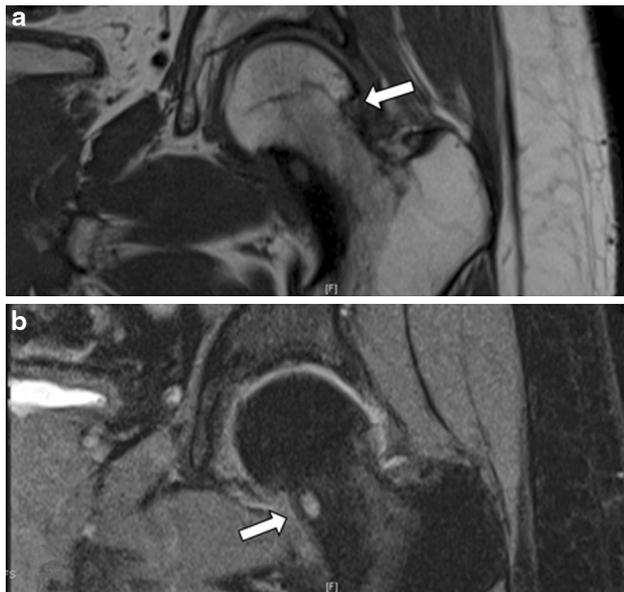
Repeat MRI image 1.5 years post-surgery. a Coronal T1 image showing post-operative changes at the femoral head-neck junction osteoplasty; b coronal T1 fat-suppressed image showing the nidus over the medial femoral neck with thickening of neck and bone marrow oedema
